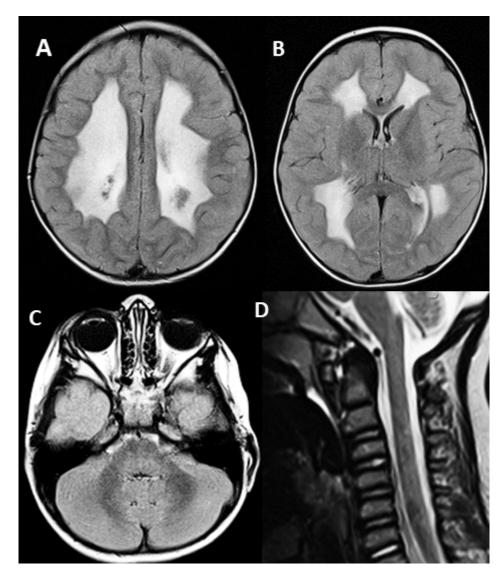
Axial FLAIR images of the brain (A-C) in a young individual (toddler) with early presentation of LBSL show abnormal signal intensity (with some areas of rarefaction) of almost all cerebral white matter, only sparing the directly subcortical areas. The internal capsule (B), brain stem (C), cerebellum (C), and spinal cord (D) are spared.
